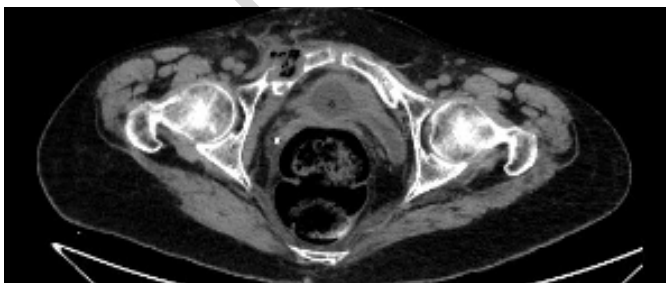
A native CT – a lesion with fracture of the right pubic bone.
